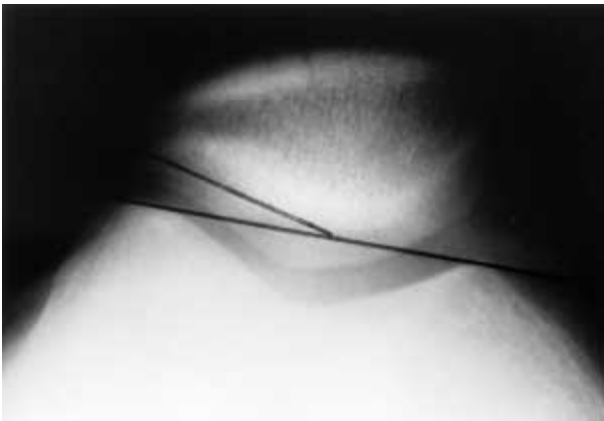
Preoperative radiograph (Laurin's view) showing normal patellofemoral angle.
